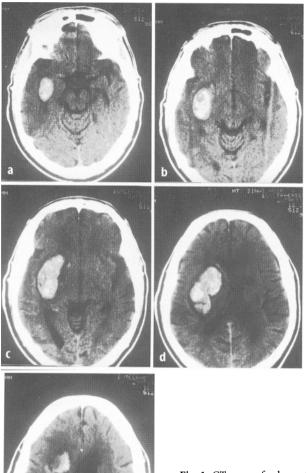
CT scan of a large (80 cc) intracerebral hematoma. The 45 year-old man presented within an hour of symptom onset with slight lethargy, good cognitive status and GCS, and normal pulse pressure when initially evaluated. By the time he returned to the emergency room after the CT scan his pulse pressure had gone up, his GCS score was 8, and he had a increased probability of death or poor outcome
